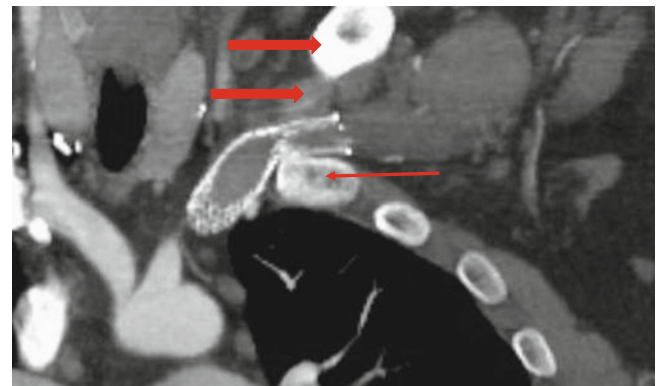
Example of a stent crushed by the first rib (*thin arrow*) and clavicle/subclavius muscle (*thick arrows*). The CT was obtained 1 year following stenting (Courtesy Sherene Shalhub, MD)
